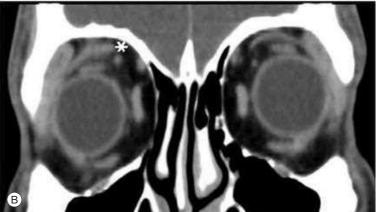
(A) Right upper eyelid retraction with 3 mm scleral show and lateral flare. (B) Coronal CT scan of same patient showing corresponding enlargement of right levator palpebrae superioris muscle (asterisk). (Courtesy Dolman PJ. Assessment and management plan for Graves' orbitopathy. In: Bahn RS, editor. Graves' disease: a comprehensive guide for clinicians. New York: Springer; 2015.)
